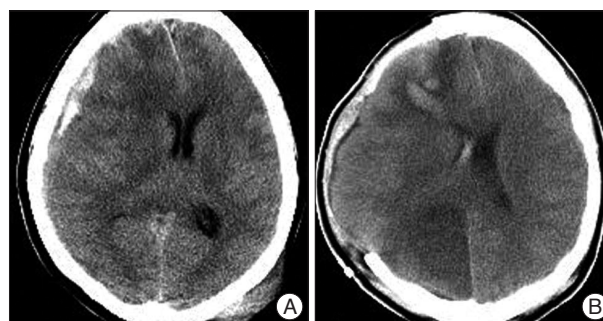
A : Computerized tomography (CT) reveals right sided acute subdural hematoma with a midline shift, B : The following CT performed after craniectomy and evacuation of blood shows PTCI in the posterior cerebral artery territory.
